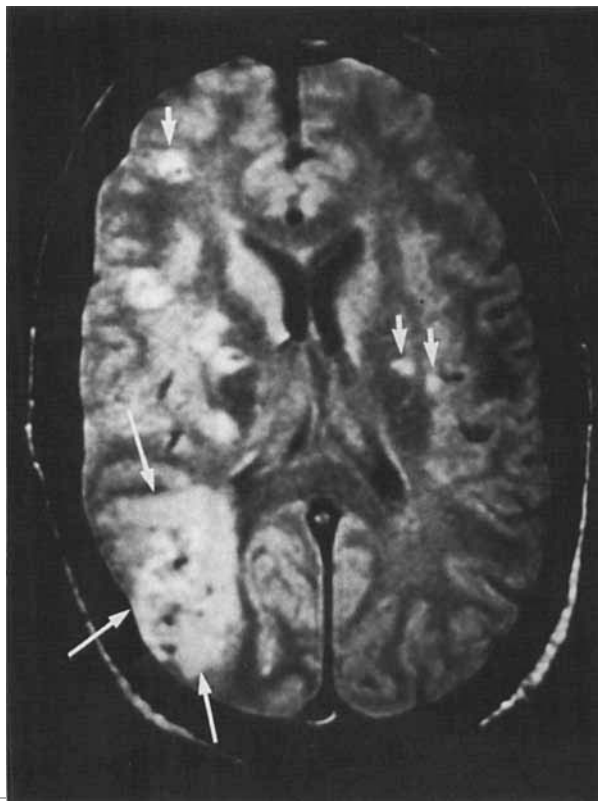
Head magnetic resonance imaging scan of Subject 2 reveals a large hemorrhagic lesion in the right temporoparietal region (long arrows); smaller deep-seated hemorrhagic lesions are seen in both hemispheres (short arrows).
